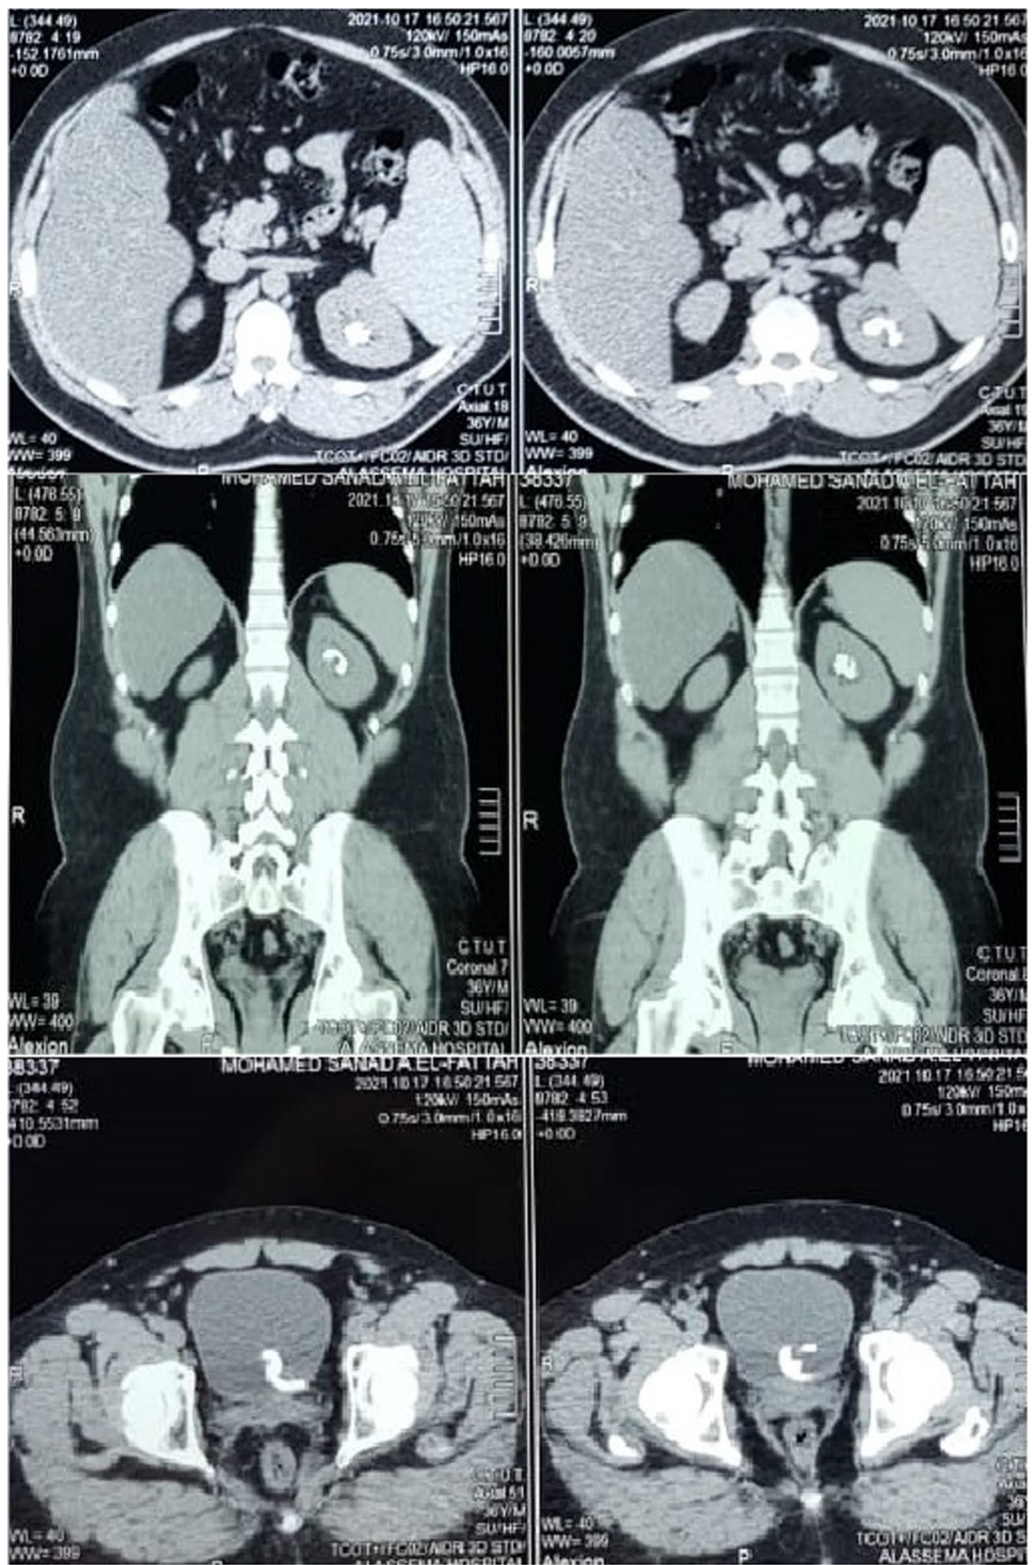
Spiral CT scan reveals left renal upper pole and urinary bladder stone on both double J stents
